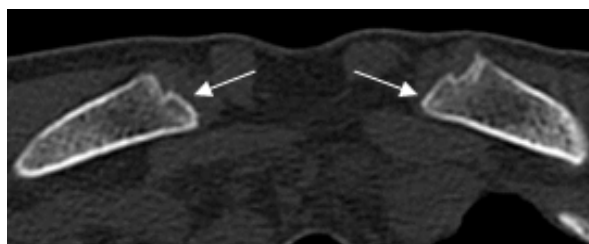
CT image of medial clavicles of 20 year old male shows that the diameter of the epiphysis is about half the diameter of the metaphysis but the fusion is complete (white arrows)
